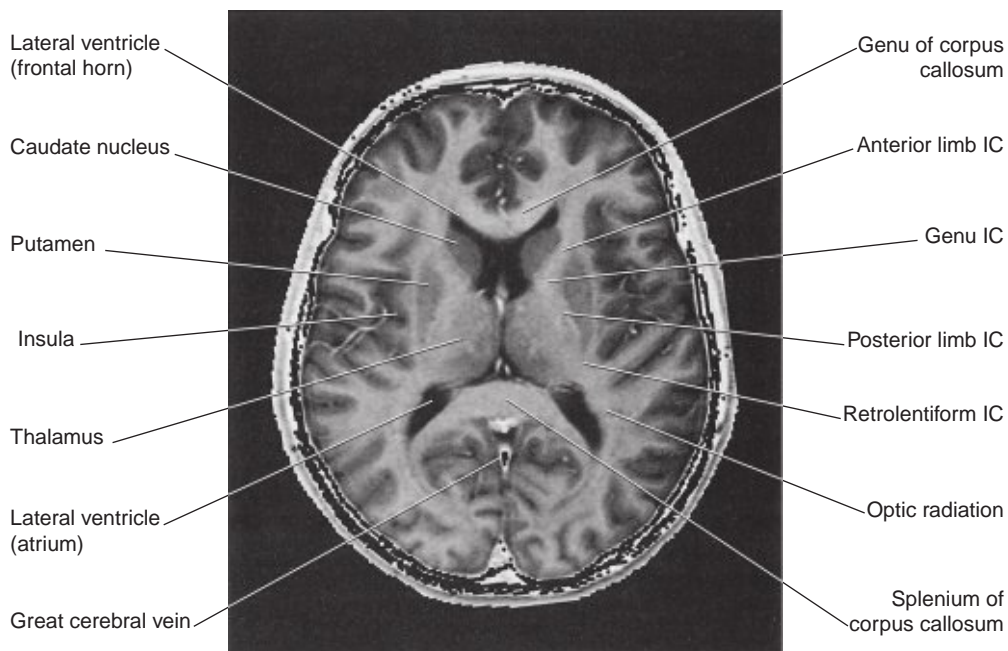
Horizontal MRI 'slice' in the plane of Figure 2.12. IC, internal capsule. (From a series kindly provided by Professor J. Paul Finn, Director, Magnetic Resonance Research, Department of Radiology, David Geffen School of Medicine at UCLA, California, USA.)
